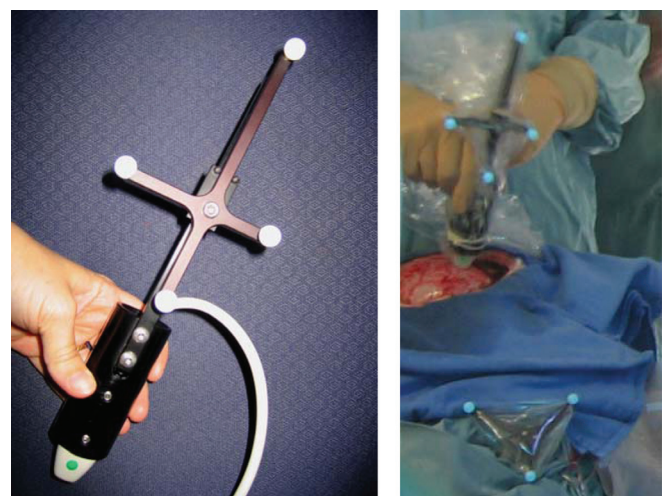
Left: ultrasound probe with tracker. Right: probe draped for surgery and image acquisition on the dura.
